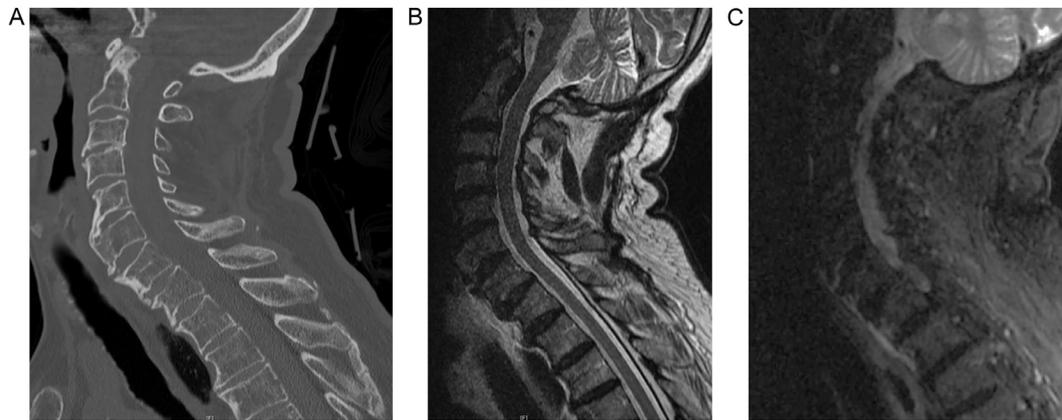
(A) In the cervical CT, there is no evidence of acute fracture. There is no misalignment and no posterior element injury. (B) Cervical MRI (T2) shows at C6–7 shearing of the disk off of the superior border of C7. (C) MRI (STIR) Hyperintense show signal extending into the anterior intervertebral disk space of C6–7 with associated prevertebral soft tissue swelling and hemorrhage anterior to the C7 and T1 vertebral bodies consistent with hyperextension. Posterior longitudinal ligaments, ligamentum flavum, and posterior interspinous ligaments are intact. Spinal cord signal is normal.
